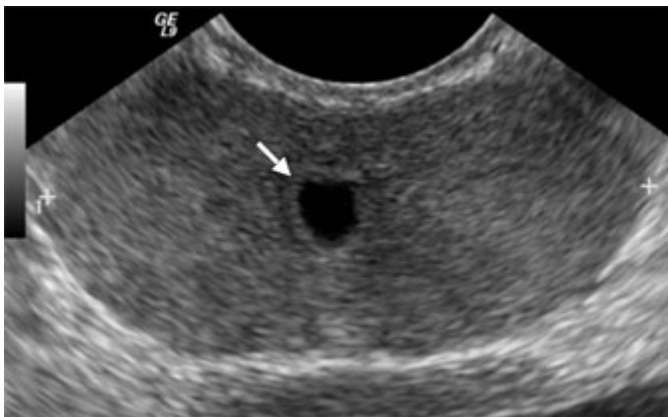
Transrectal ultrasound of the prostate. Transverse image of the prostate in a young male demonstrates a small midline cystic structure (arrow), thought to represent a utricle cyst. In addition to detecting cystic lesions, trans-rectal ultrasound of the prostate is also used to evaluate the seminal vesicles and the vas deferens for congenital abnormalities.
